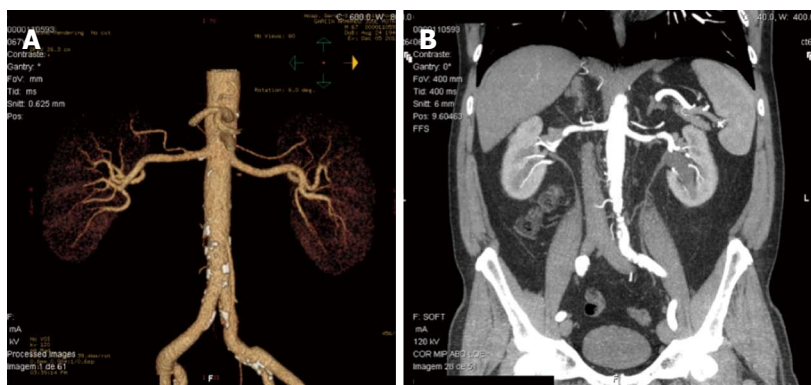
Computed tomography angiography revealing normal renal arteries of a resistant hypertension patient.
